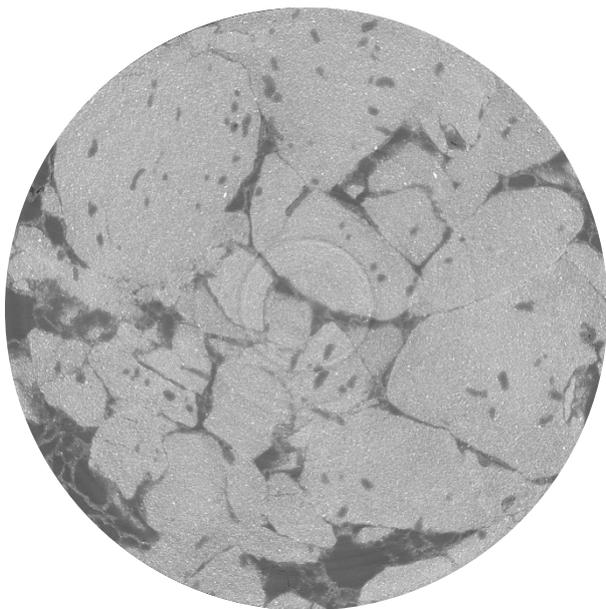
The 3D reconstructed X-ray micro tomography data with application of phase retrieval filter algorithm of a 9.0% (m/m) moxidectin mini-tablet with a diameter of 2mm [128]. The dark grey substance is the drug moxidectin, the light grey shows the granules and the embedded dark grey particles in the light grey phase are disintegrant.
